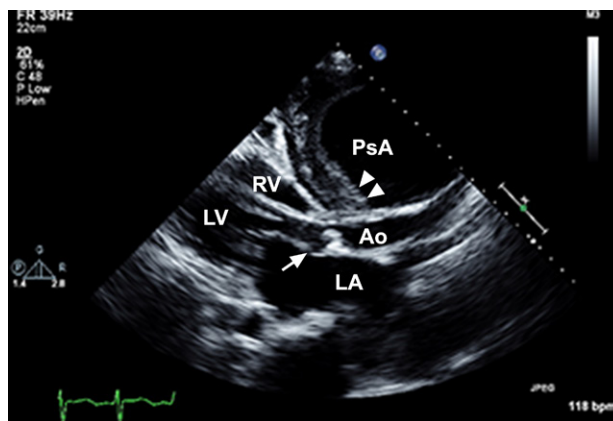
Transthoracic echocardiogram (parasternal long-axis view) shows a large pseudoaneurysm (PsA) arising from the aorta and lined by intramural thrombus (arrowheads). The pseudoaneurysm compresses both ventricular cavities. The arrow points to the mitral valve.
